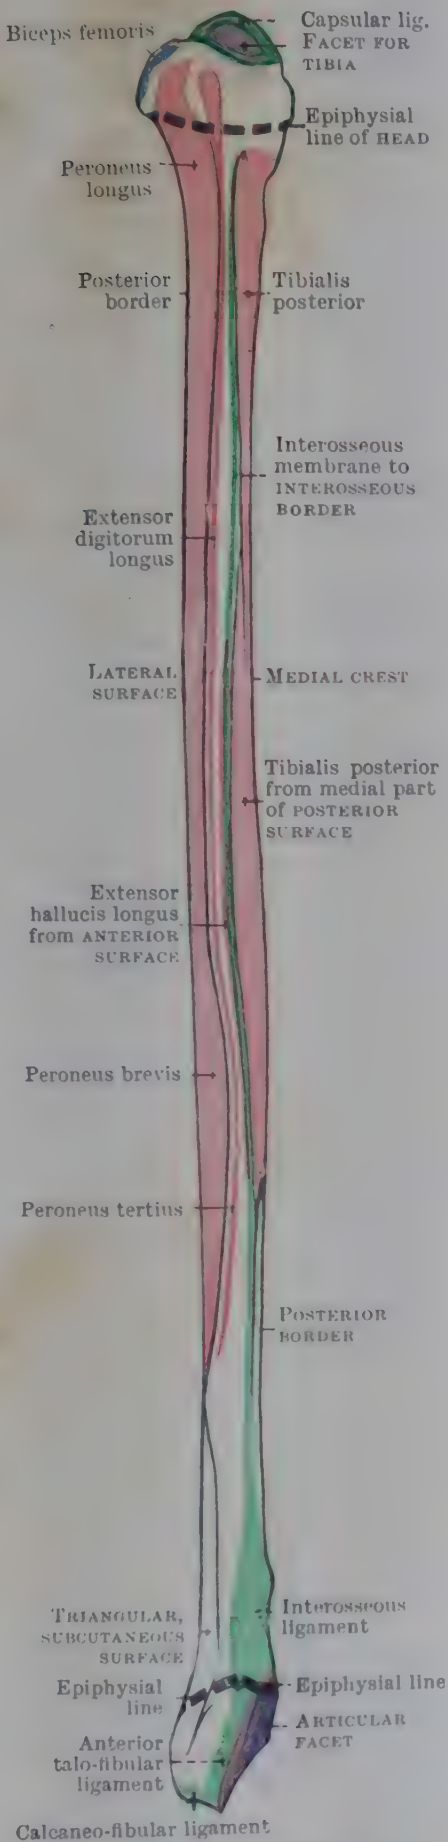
ANTERIOR ASPECT OF RIGHT FIBULA.
